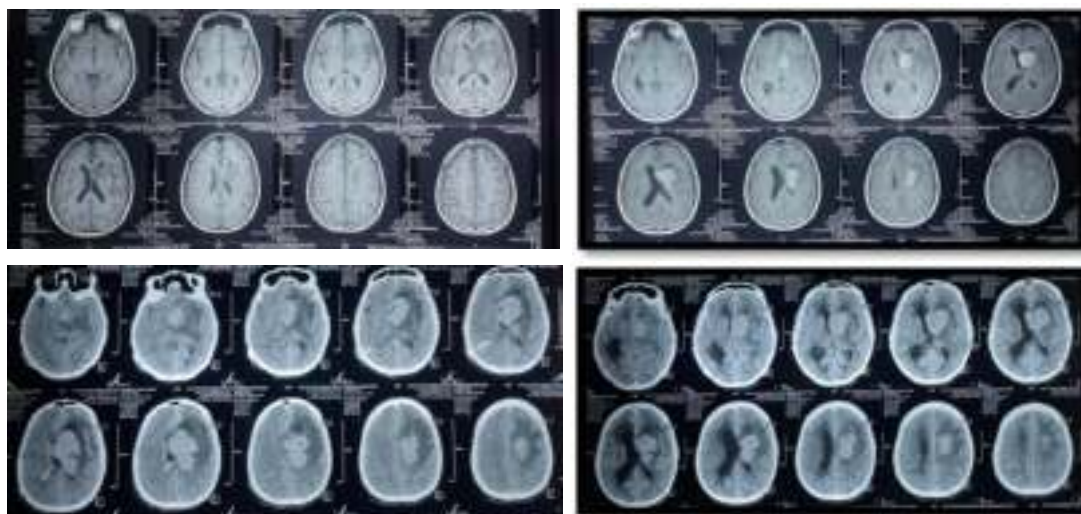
Brain MRI Patients Before Chemotherapy.
